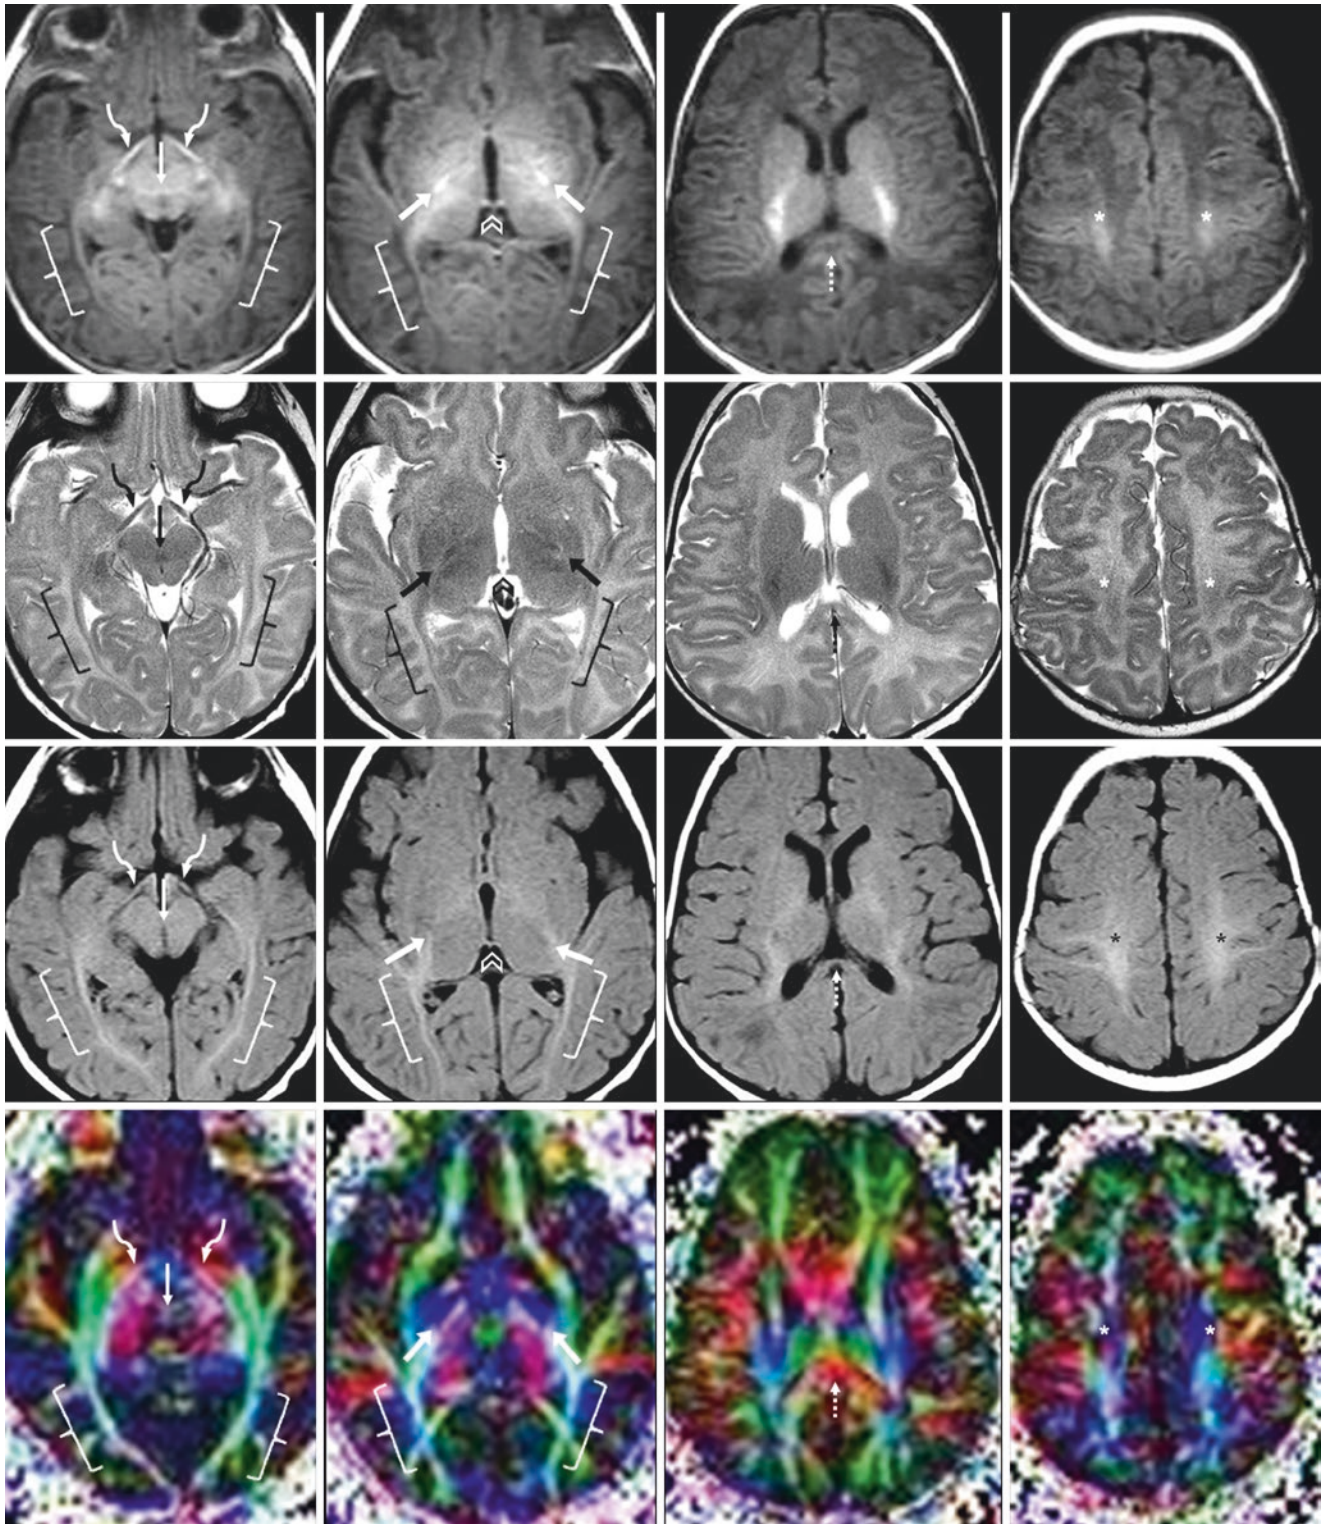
An 8-week-old with questioned trauma but a negative 3T MRI, who thereafter developed normally. *Top row:* GE T1WIs depict clear myelination of the optic tracts (*curved arrows*), DSCP (*thin arrow*), HC (*chevron*), and PLICs (*arrows*). The centrum semiovale continues to brighten (*asterisks*). *Second row:* SE T2WIs show evident myelination in the same structures; the HC and optic tracts are now clearly myelinated. Also, note darkening of the optic radiations (*brackets*) and CS (*dotted arrow*), better seen on SE T2WI. *Third row:* FLAIR images
